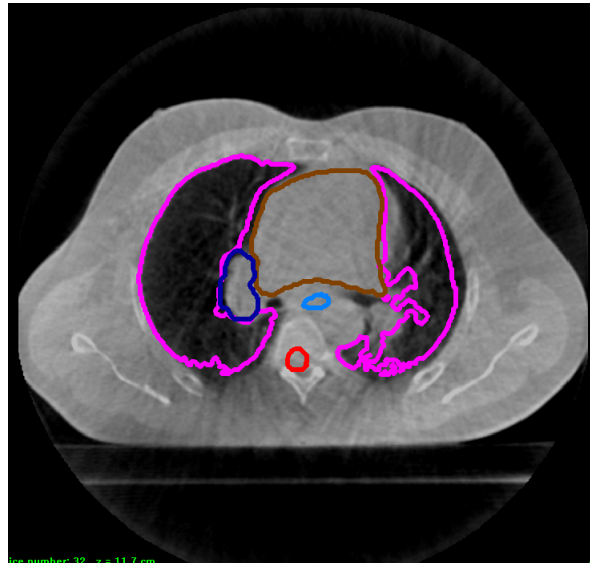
An example slice of a delineated CT treatment planning scan. The density of the tissue is shown by its brightness with the most dense tissue in white and the least dense in black. A variety of delineations are shown here; ITV (dark blue), heart (brown), oesophagus (light blue), lung walls (purple) and spinal column (red).
